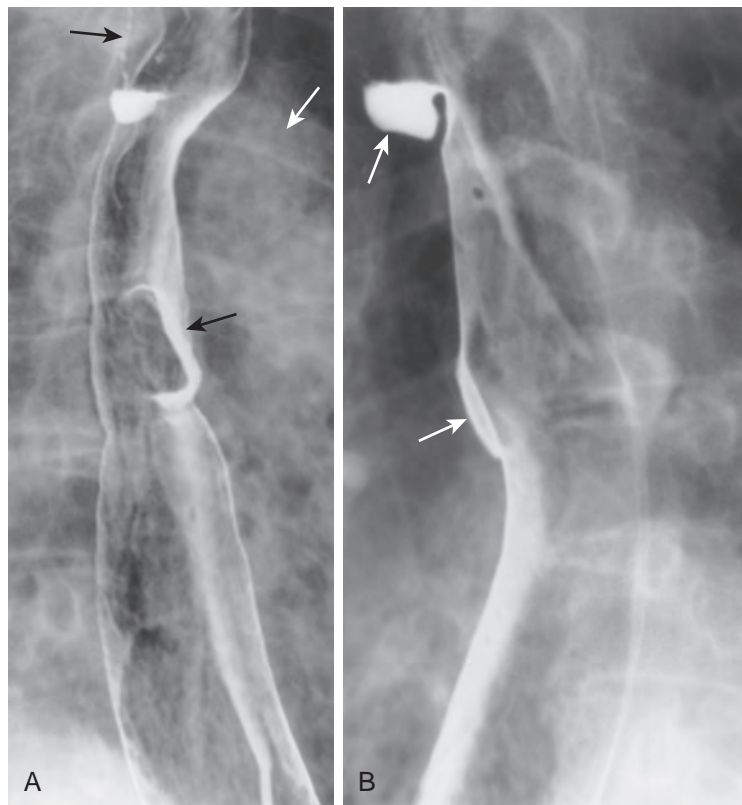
Wide-mouthed sacculations in scleroderma. A. Two large sacculations are seen en face (black arrows) in the upper and midesophagus. Note how the upper sacculation extends superiorly just above the level of the aortic arch (white arrow). B. Additional view with the patient turned 90 degrees shows the sacculations in profile (arrows). (From Coggins CA, Levine MS, Kesack CD, et al: *Wide-mouthed sacculations in the esophagus: A radiographic finding in scleroderma*. AJR 176:953–954, 2001.)
